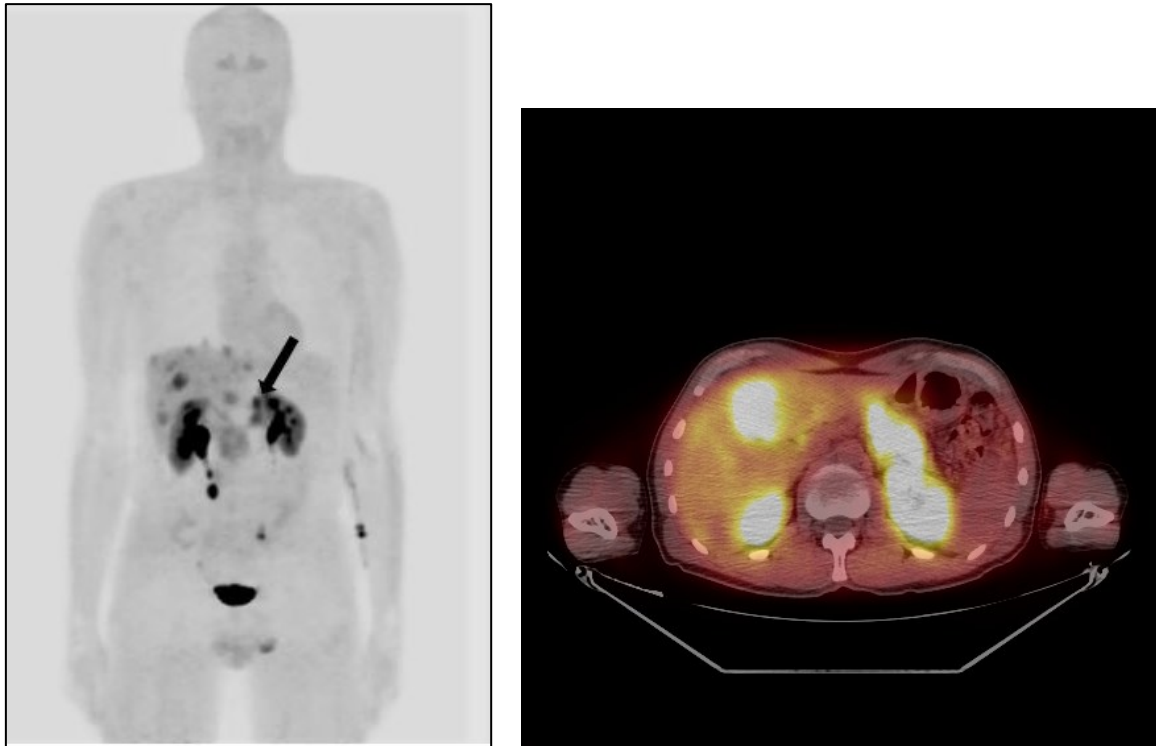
^{18}F -DOPA PET/CT MIP and axial PET/CT of the same patient
